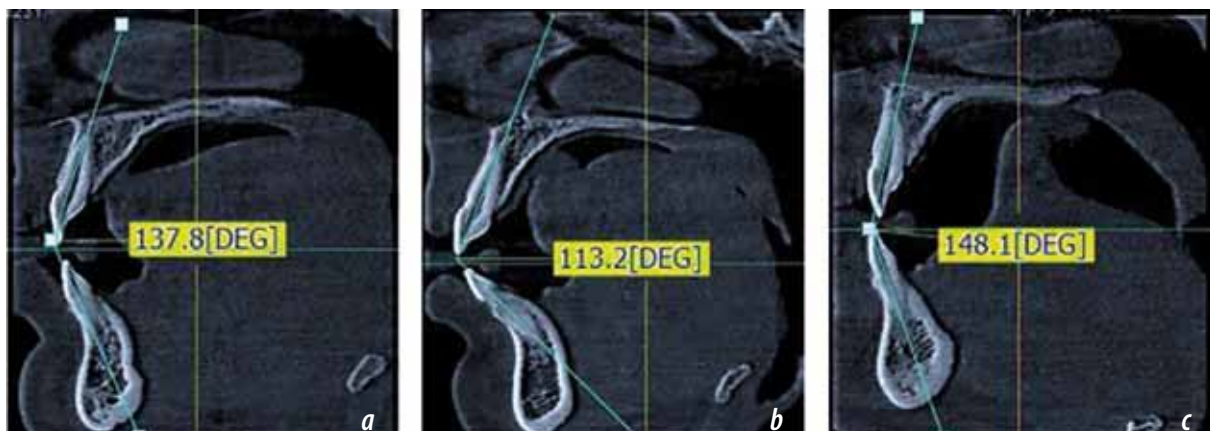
Variants of the location of the medial incisors on the CBCT images: a — mesotrusion type of dental arches; b — protrusion type of dental arches; c — retrusion type of dental arches
